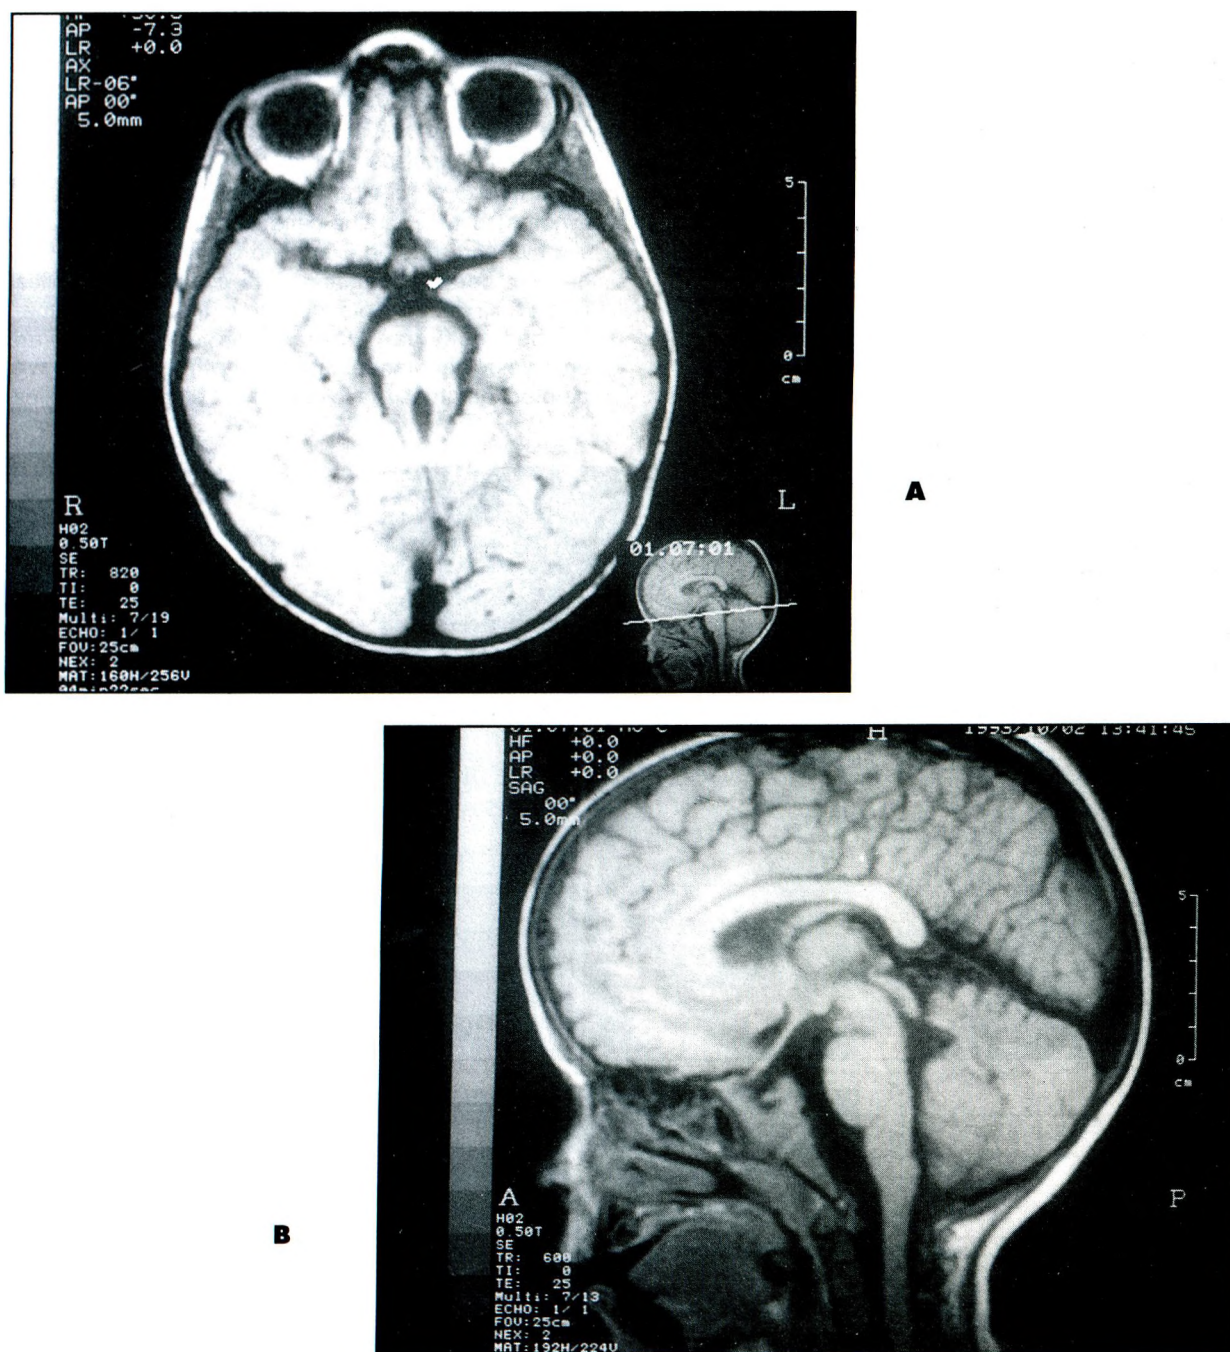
Case 2: T1-weighted axial (A) and sagittal (B) images show partial agenesis of cerebellar vermis and dysplastic appearance of superior cerebellar cortex
